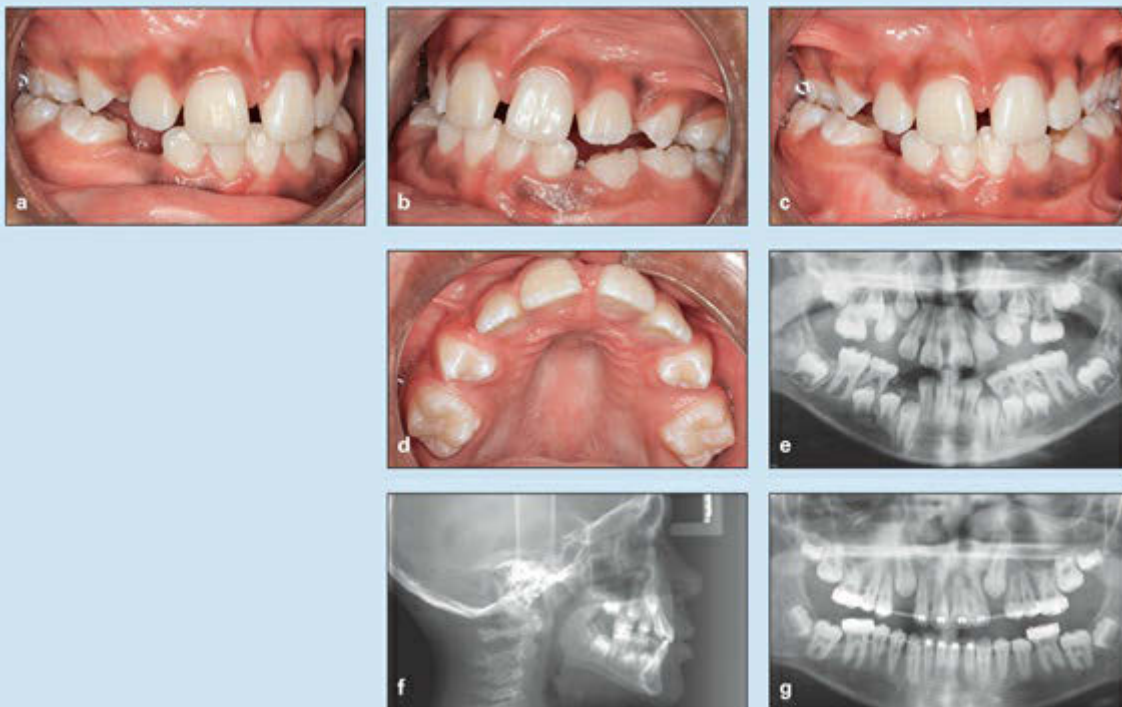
Space creation in a 10-year-old boy with severe space deficiency resulting from early loss of primary teeth and the lack of any space management. (a to d) Pretreatment occlusion. (e) Pretreatment panoramic radiograph. (f) Pretreatment cephalometric radiograph. (g) Panoramic
